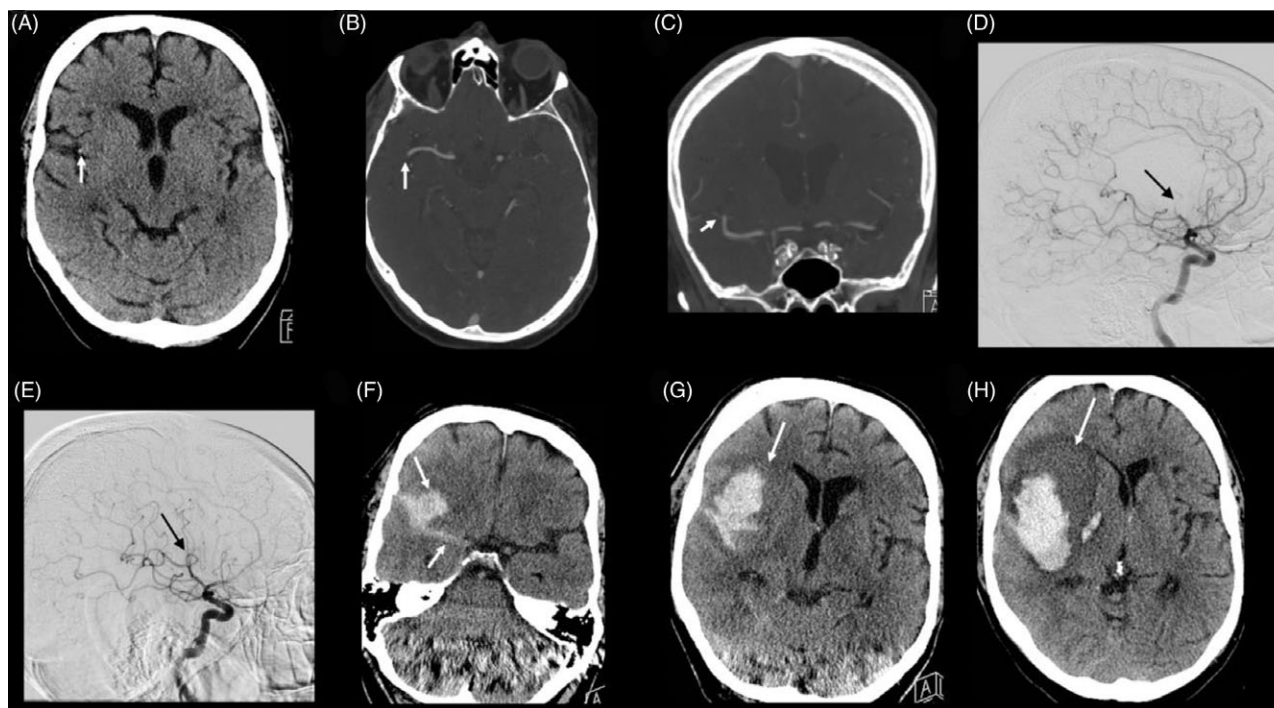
Diagnostic imaging, therapeutic intervention, and follow-up scan for the second case reported. (A) Axial CT head reveals a right distal MCA hyperdense sign in the sylvian fissure correlating with right M2 occlusion. (B and C) Axial and coronal CTA show proximal occlusion of M2 segment of the MCA. (D) Digital subtraction angiogram further demonstrates the same finding shown in CTA. (E) Digital subtraction angiogram shows revascularization after a successful EVT. (F, G, and H) Axial CT head after tPA EVT reveals right frontoparietal SAH and large ICH surrounded by edema.
